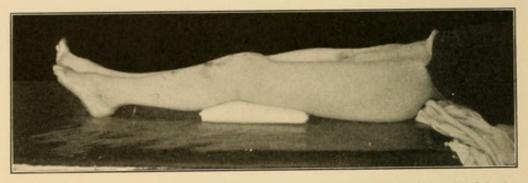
Case: Boy, eleven years of age. Separation of the lower femoral epiphysis. Photograph taken four hours after the injury. Note inversion of the limb; fullness of lower third of thigh posteriorly; fullness over head of tibia; fullness in popliteal space (X-ray tracing, Fig. 434, explains the evident deformity).
